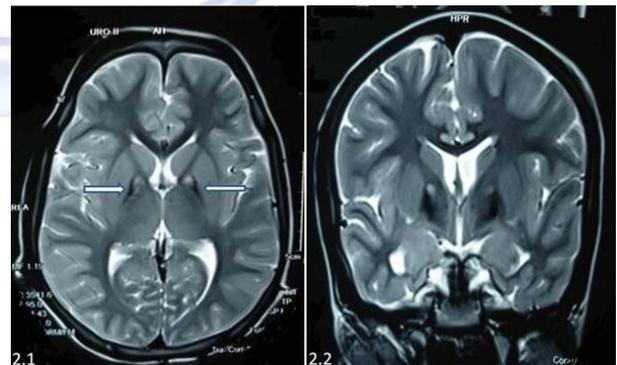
MRI brain showing T2 axial (2.1) and coronal (2.2) images: Bilateral symmetrical hypointensity in globus pallidus with central hyperintensity “eye of tiger sign”.
